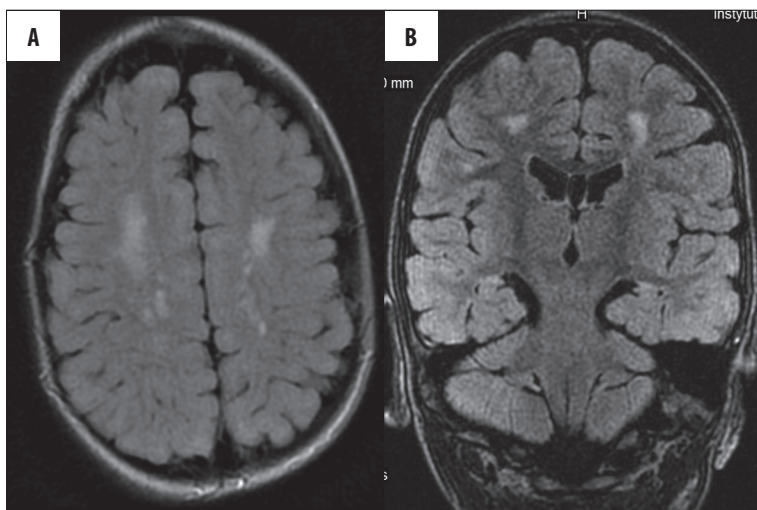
A rare case of isolated injury to subcortical white matter with no damage to periventricular white matter. (A) FLAIR,ax; (B) CUBE/3D/FLAIR,cor.
